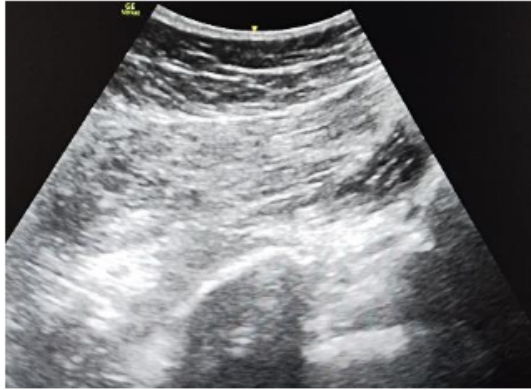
Sonographic identification of the piriformis muscle on the BL54 acupoint
